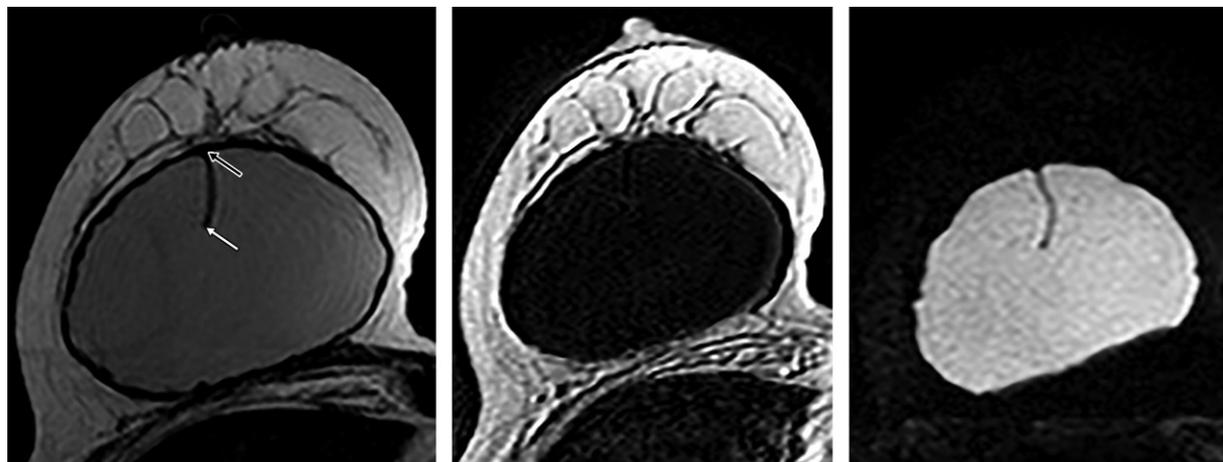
Normal single-lumen silicone implant at MR imaging. (a) Axial T2-weighted MR image shows a single-lumen implant with silicone gel producing homogeneous intermediate signal intensity. A normal radial fold emanates from the anterior aspect of the implant. Black arrow = base of radial fold, white arrow = apex of radial fold. (b) Axial T1-weighted MR image with silicone suppression shows that silicone gel displays homogeneous hypointense signal intensity. (c) Axial inversion-recovery MR image obtained with both fat and water suppression shows that silicone gel demonstrates the only bright signal intensity within the breast.
